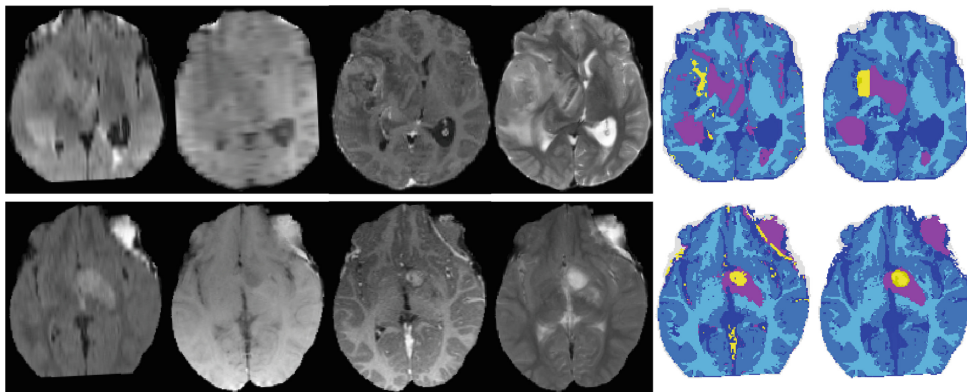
Slices of five exemplary subjects, 2015 training data. The last subject has a low-grade tumor and the rest high-grade tumors. From top to bottom: MR-contrasts: FLAIR, T1, T1c and T2; ground-truth segmentation; initial GEM-segmentation; and final segmentation. Healthy labels are in blue to cyan, edema is in lilac and core is in different shades of yellow (Color figure online).
